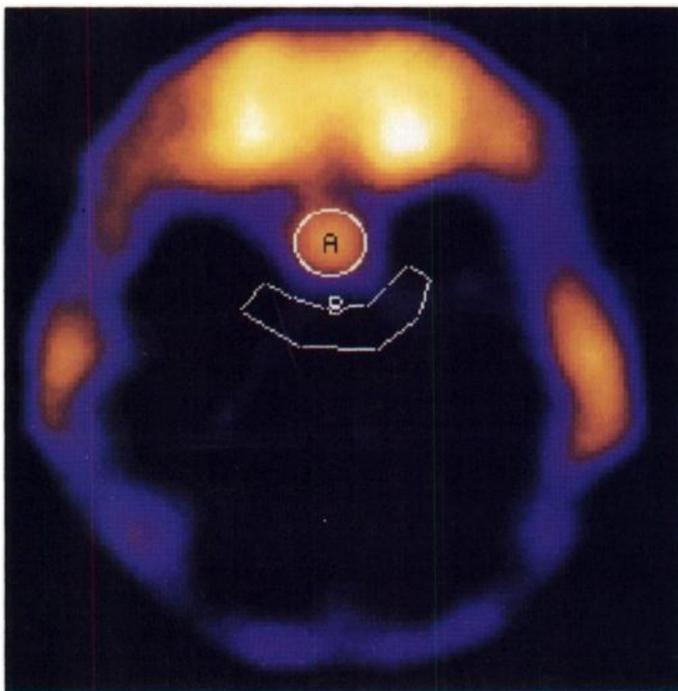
SPECT study of the pituitary gland in a 23-yr-old man (volunteer) 24 hr after i.v. injection of 56 MBq of $[^{111}\text{In-DTPA-D-Phe}]$ -octreotide. Standardized ROI according to Method 2 was placed over the pituitary gland area as well as the background area.
